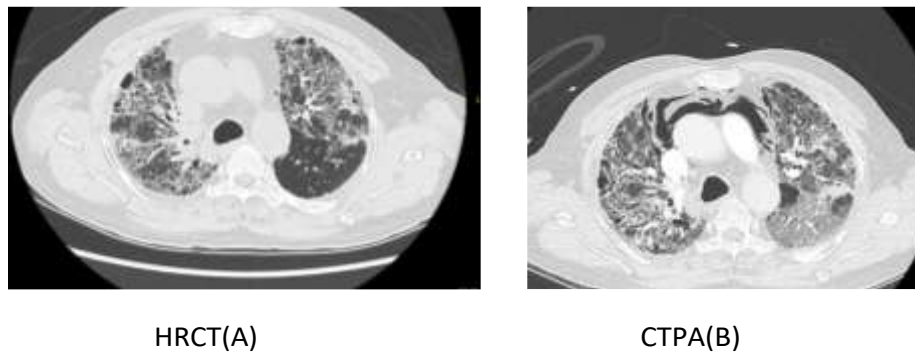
HRCT(A) and CTPA (B) at the level of end of aortic arch showing pneumomediastinum in CTPA
